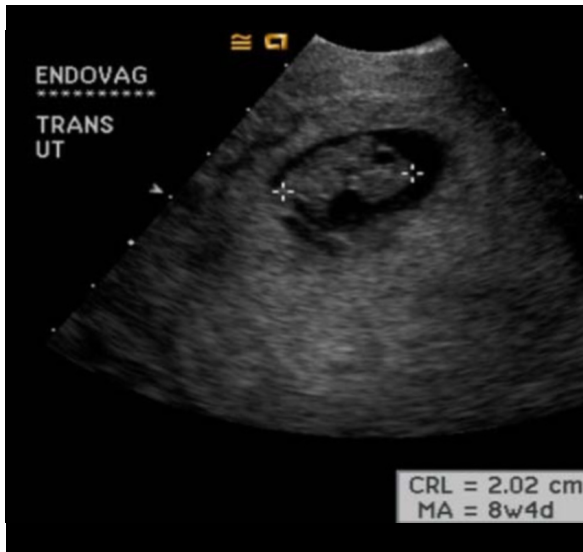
Follow-up to surgical excision of the right tubal pregnancy. Follow-up transvaginal ultrasound demonstrates continued appropriate growth of the intrauterine gestation now measuring 2 cm corresponding to a gestational age of 8 weeks 4 days.
